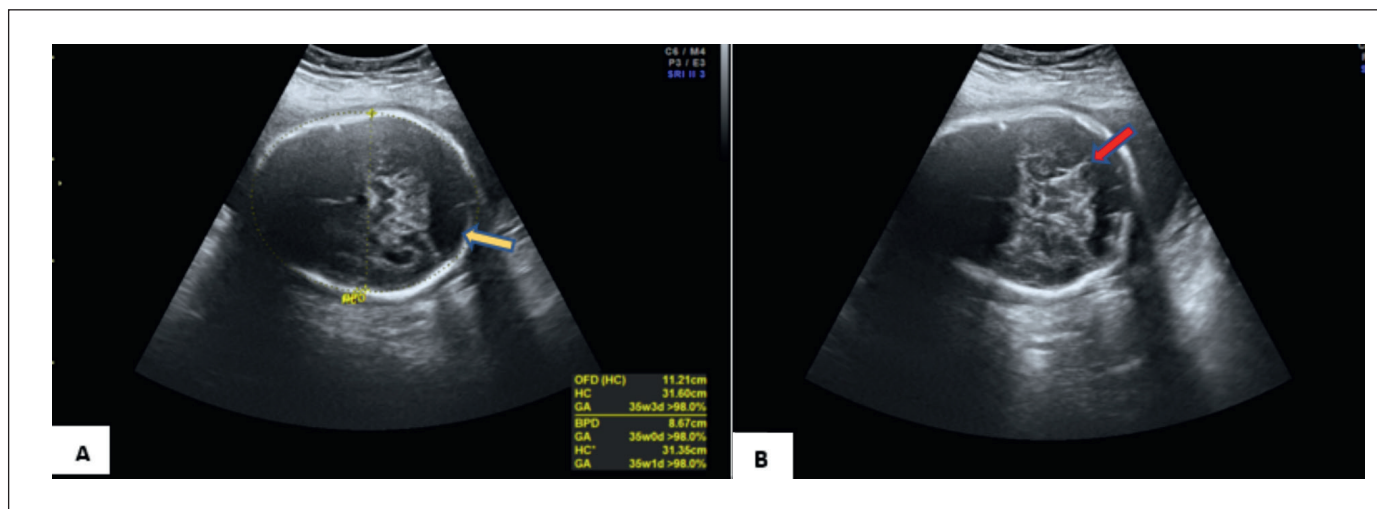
(A) Obstetric ultrasound at 35 weeks 3 days presenting large posterior fossa cyst (yellow arrow), and (B) cerebellar hypoplasia (pink arrow), which is not evident due to a shadowing artifact.
